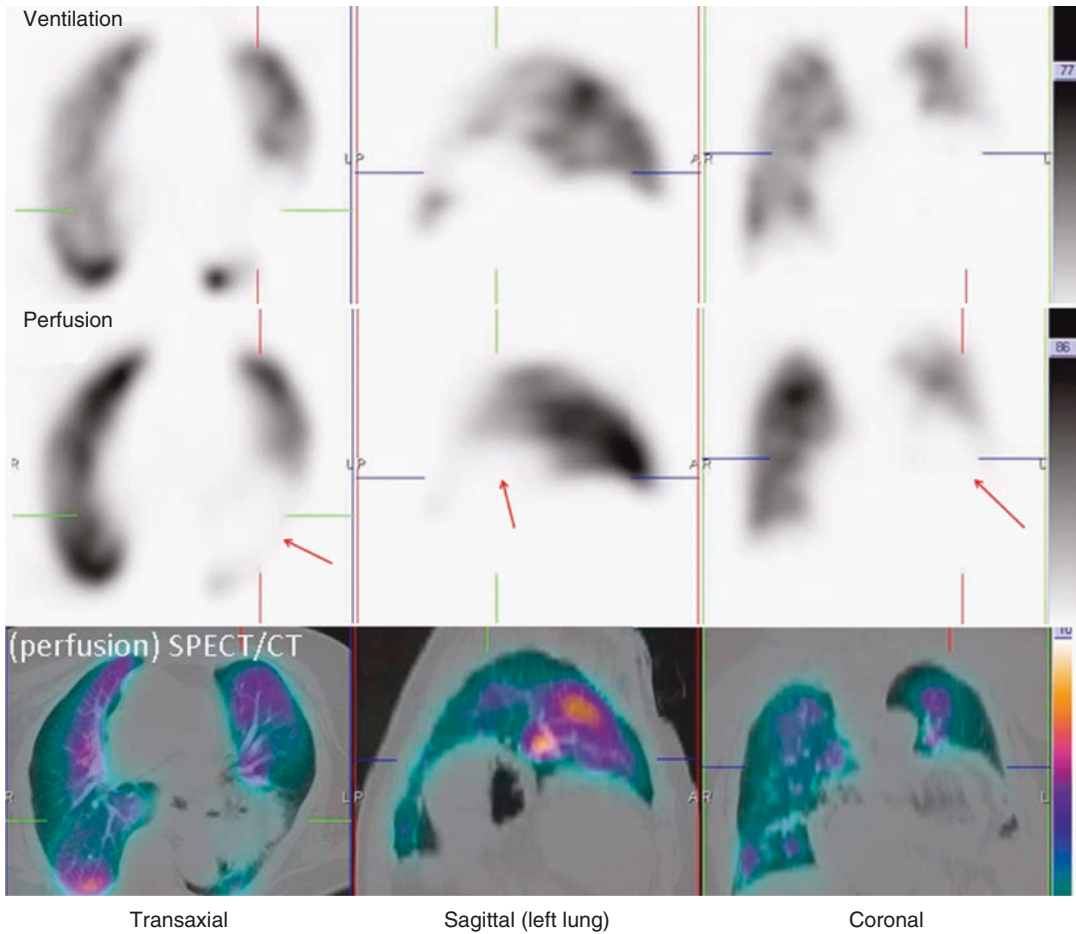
Representative ventilation, perfusion and SPECT/CT images in a 63-year-old male with chest pain. A large matched defect is evident on SPECT in the left
